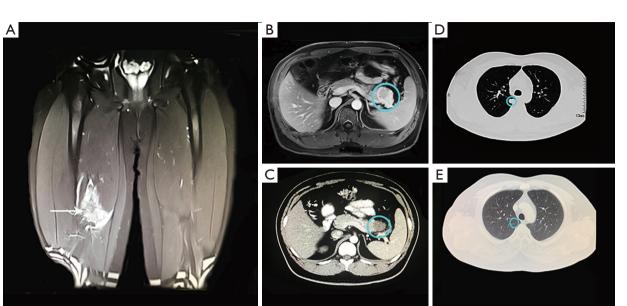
Imaging evaluation of apatinib combined with camrelizumab antitumor activity. (A) T2 arterial phase magnetic resonance imaging showing the primary alveolar soft part sarcoma (ASPS) tumor in the right anterior thigh (white arrow). (B) T2-weighted MRI showing the pancreatic lesion (blue circle). (C) Contrast-enhanced computed tomography (CT) scan showing regression of the pancreatic lesion 4 months after the combination therapy. (D) Right lung metastases (blue circle) before treatment. (E) Contrast-enhanced CT scan showing tumor regression in the lung after six cycles of combination therapy.
